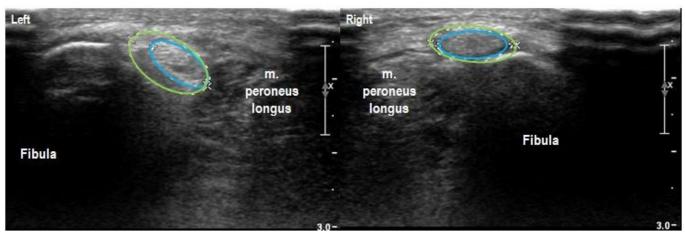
Ultrasound case 4: no obvious differences between the left and right nerve, due to the fact that both nerves were affected.
